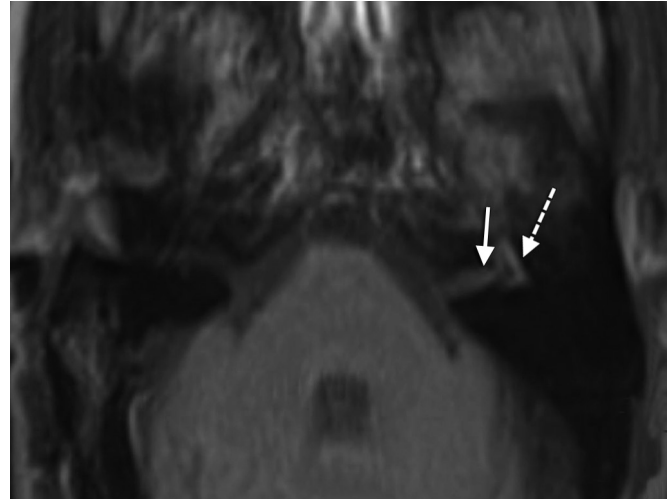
Bell's palsy. Axial fat-saturated, contrast-enhanced T1-weighted MR image shows abnormal, linear asymmetrical enhancement of the left labyrinthine (solid arrow), anterior genu and proximal tympanic (dashed arrow) segments of the facial nerve, compatible with Bell's palsy.
